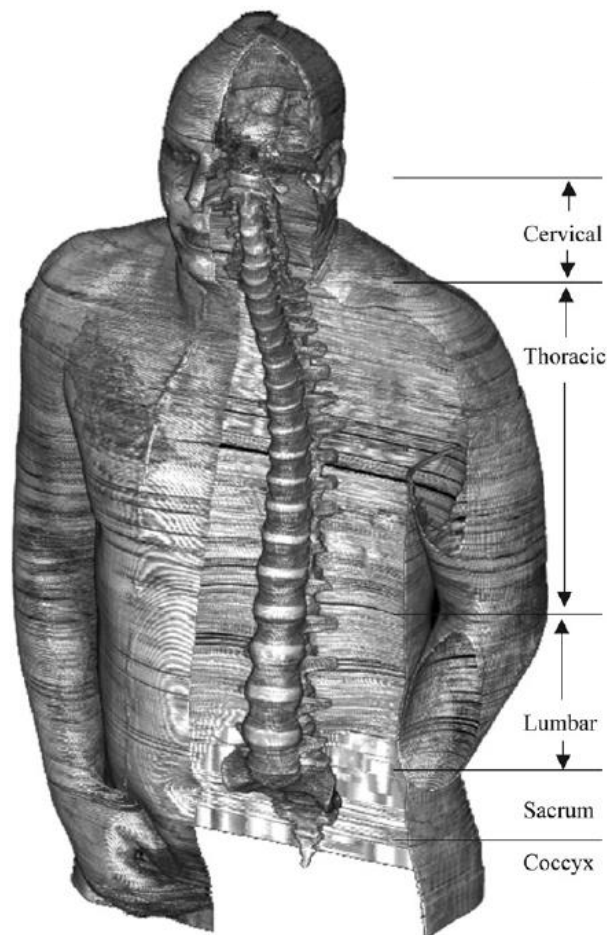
MRI of the vertebral column highlighting the different regions of the spine [27].
